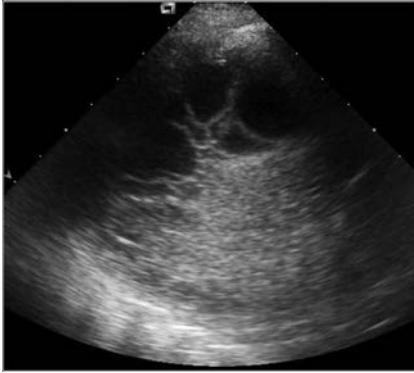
Chest ultrasound showing a loculated pleural effusion.
